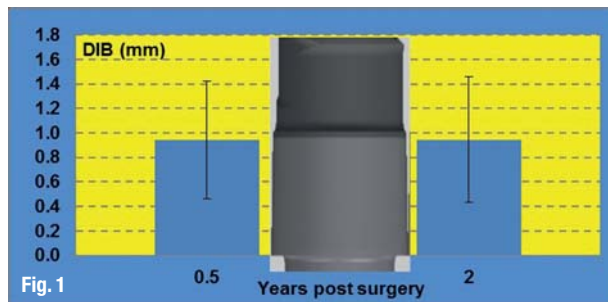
Peri-implant (mesial and distal) bone level around short implants six months (0.5 years) and two years after implant insertion. The implant shoulder is included to visualise the periapical bone level also in relation to the implant geometry.
